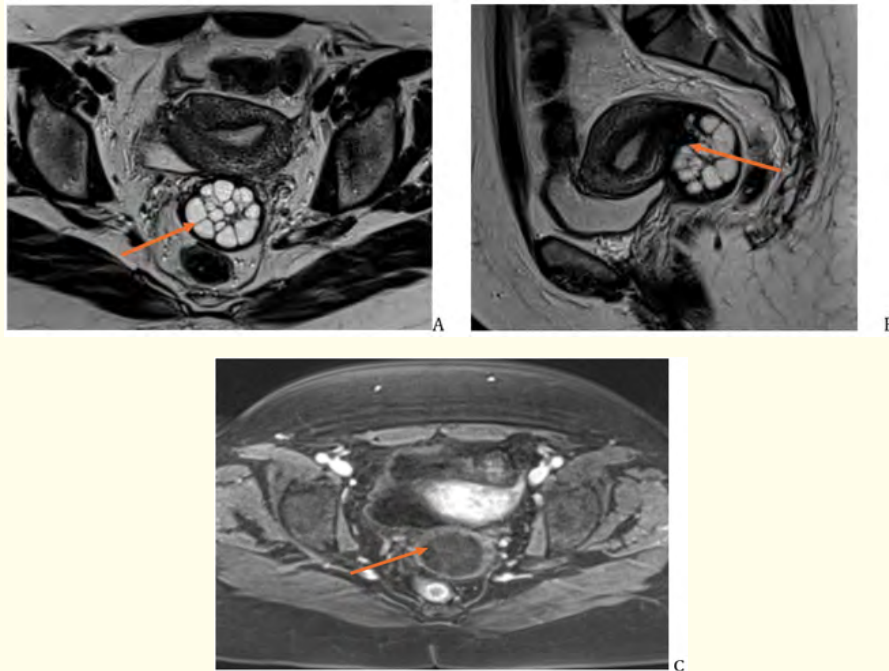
Figure A-C: T2-weighted axial (A) and sagittal (B) sequences show a multicystic cervical mass measuring $5.5 \times 4.5 \times 6$ cm. The mass exhibits high T2 signal intensity consistent with fluid content, low T1 signal intensity, and no intralesional enhancement (C) or pathological nodule. There is no solid tissue component. The lesion extends into the endocervix.
